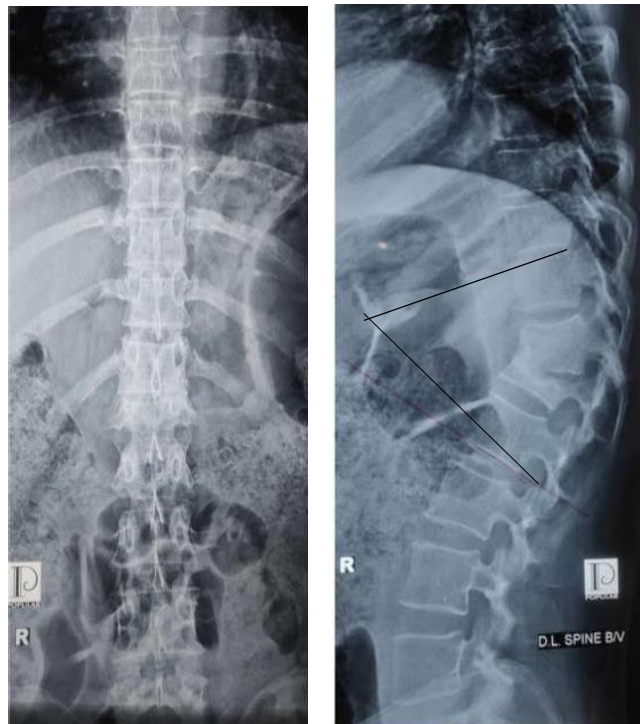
Pre-operative X-ray of D/L spine (A/P and lateral view) showing post tubercular kyphotic deformity at dorso lumbar region with kyphotic angle 35°.
